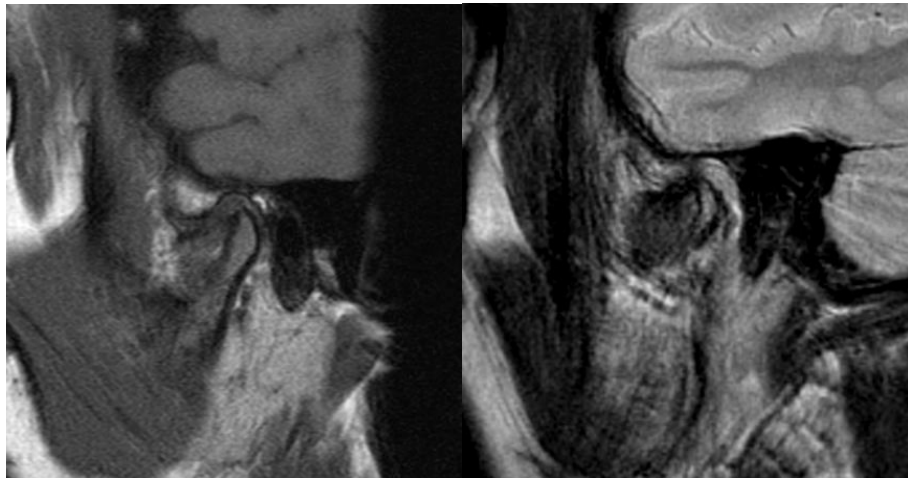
Pre-Treatment Sagittal T1 (a) and T2 (b) Weighted MRI of Right Temporomandibular Joint (TMJ) in closed mouth position show a partial anterior disc displacement
